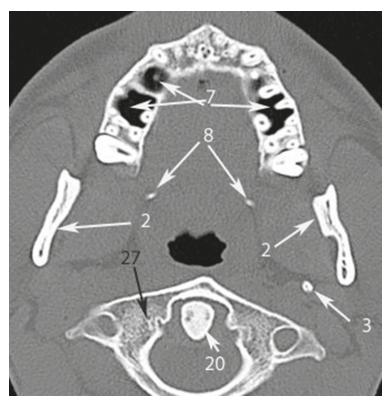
Axial CT scan at the lower third of the maxillary sinus. *Numbers* with *arrows* denote the following anatomical structures: 2 – inner surfaces of the mandibular rami; 3 – styloid process of the temporal bone; 7 – maxillary sinus; 8 – the pterygoid hamulus; 20 – odontoid process (dens) of the axis (is a second cervical vertebra (C2)); 27 – atlas (is a first cervical vertebra (C1)).
